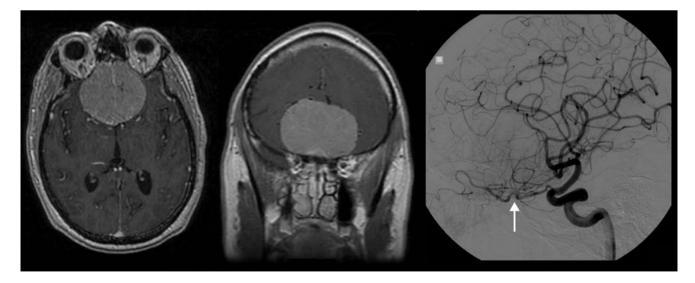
Images from a case of a 60-year-old male who presented with several months of decreased concentration, abulia, and loss of smell who presented with a seizure. Axial (*left*) and coronal (*middle*) post-contrast T1-weighted images demonstrate a $5.9 \times 4.5 \times 5.4$ cm
